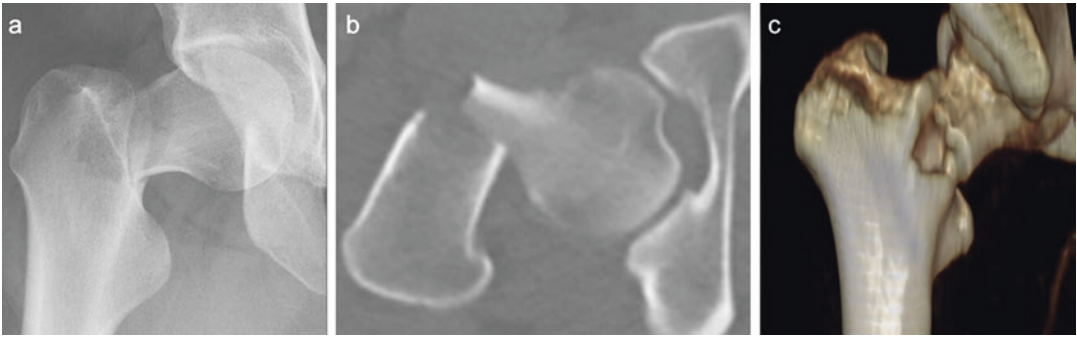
(a) AP radiograph of the right hip. (b, c) CT scan of the pelvis including the right hip
